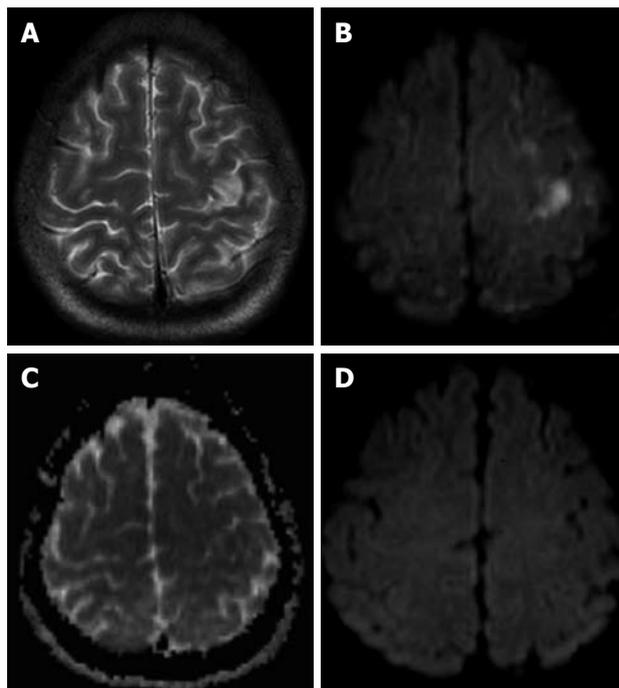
A 36-year-old man with cerebral lipiodol embolism. A: Axial T2-weighted imaging (T2WI); B: Diffusion-weighted imaging (DWI); C: Apparent diffusion coefficient (ADC); D: Follow-up DWI. A, B and C obtained 57 h after the second TACE, and D obtained 5 wk after the second TACE. T2WI and DWI (A, B) demonstrated multiple high-signal lesions on the bilateral frontal and parietal lobe. The corresponding lesions showed a low signal area on the ADC map (C). A follow-up DWI revealed no obvious abnormal signal (D).
